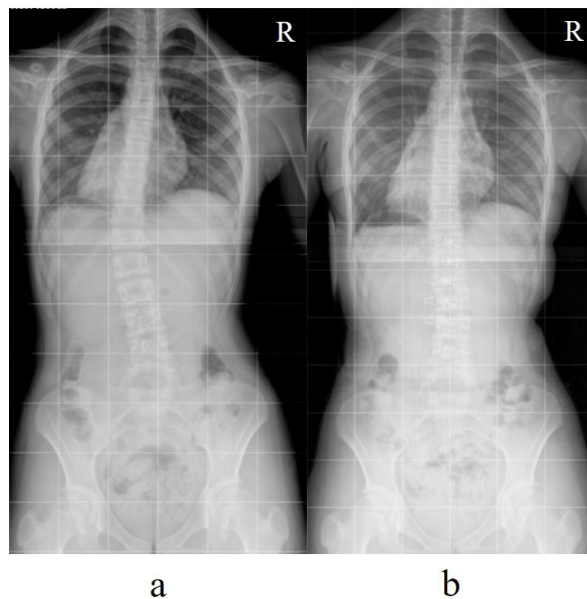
Radiograph images of Subject 19002: (a) without brace, and (b) with brace
